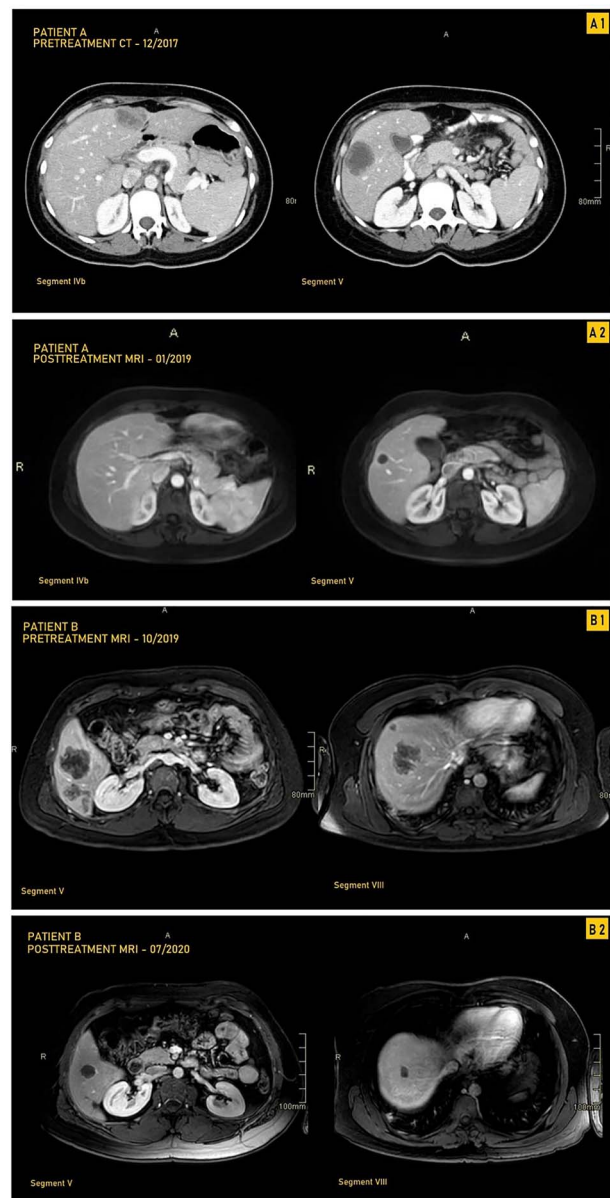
CT and MRI images of our two patients before and after treatment with pembrolizumab; (A1) Pretreatment MRI of our first patient in September 2017 showing most prominent lesions, located in Segments IVb and V, on axial enhanced CT after contrast administration; (A2) Posttreatment axial enhanced T1-weighted MRI of our first patient in January 2019 showing most prominent lesions located in Segments IVb and V; the lesion in Segment V is smaller, measuring 1.4 cm, and is completely necrotic; (B1) Pretreatment axial enhanced T1-weighted sequence MRI performed on 3Tesla field strength following gadolinium contrast administration in our first patient in October 2019 showing most prominent lesions, located in Segments V and VIII; the largest metastatic lesion is a 4.8-cm heterogeneously enhancing metastatic lesion in Segment VIII; (B2) Posttreatment axial enhanced T1-weighted sequence MRI performed on 3Tesla field strength following gadolinium contrast administration in the hepatobiliary phase in our second patient in July 2020, showing most prominent lesions located in Segments V and VIII; the largest lesion in Segment VIII decreases in size to 1.5 cm following treatment and is completely necrotic.
